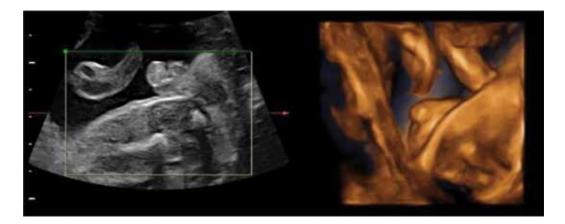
Hypospadias: the left-side image is the 'tulip sign' in 2D conventional ultrasound; the right-side image is a 3D reconstruction, surface rendering technique.
